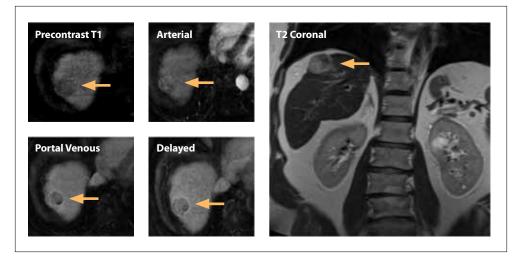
Examples of early-stage hepatocellular carcinoma seen on abbreviated magnetic resonance imaging protocols.
